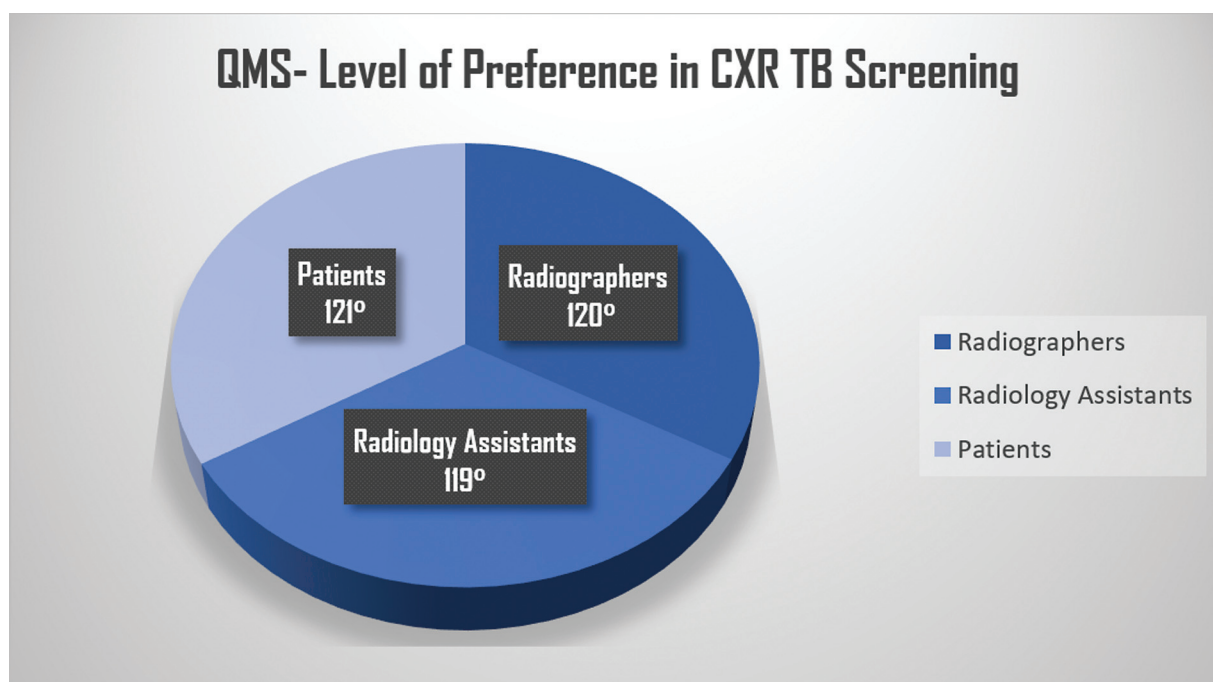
Queue management system (QMS) level of preference in chest radiography-tuberculosis (CXR-TB) screening: Pie chart depicting numerical proportion on QMS preference among radiographers, radiology assistants, and patients. An almost equal size of data representation for each respondent category.
